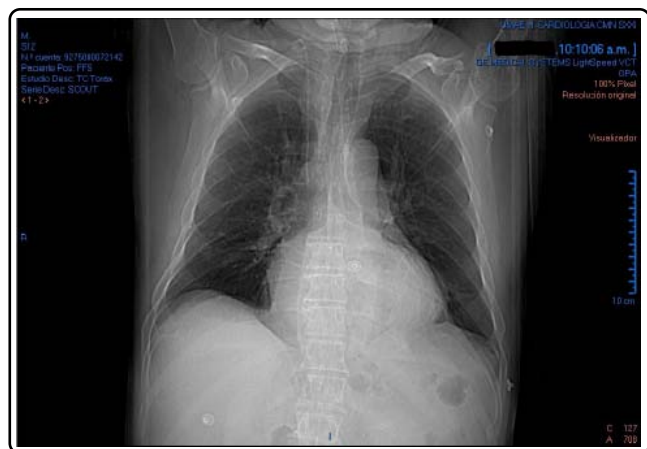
CT topogram of the chest shows a slightly grown heart with the right interlobar artery oversize, the heart has the right ventricle enlarged.
